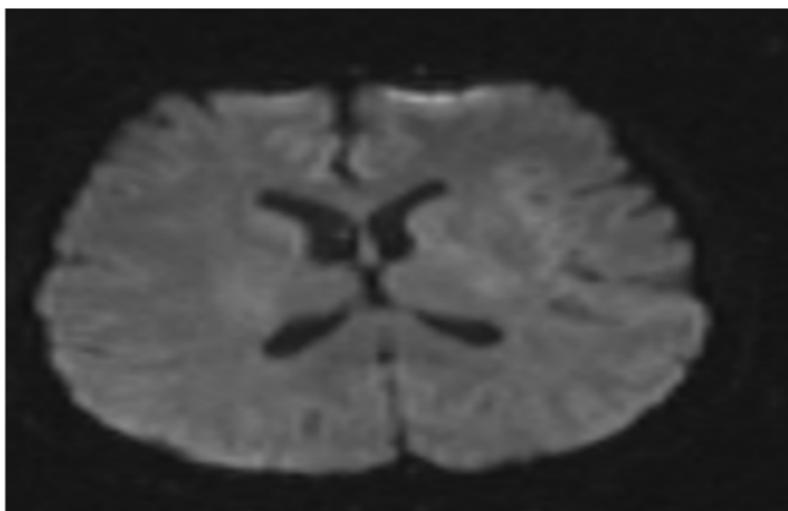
Figure Brain MRI Showed No Acute Infarction
